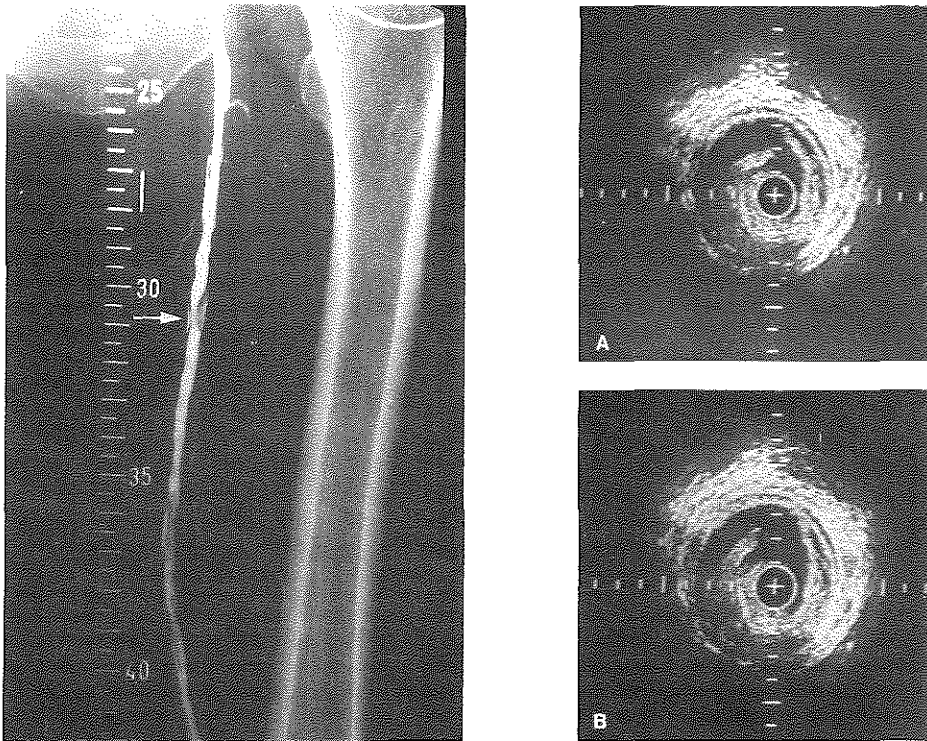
Angiogram and intravascular ultrasound cross-sections of the superficial femoral artery obtained after balloon angioplasty. The angiogram reveals a distinct dissection at level 31. Ultrasound cross-sections obtained at the corresponding level (31) evidenced plaque dissection. Pulsatile flow resulted in a slight difference between the images (A = diastole; B = systole). Calibration 1 mm.
